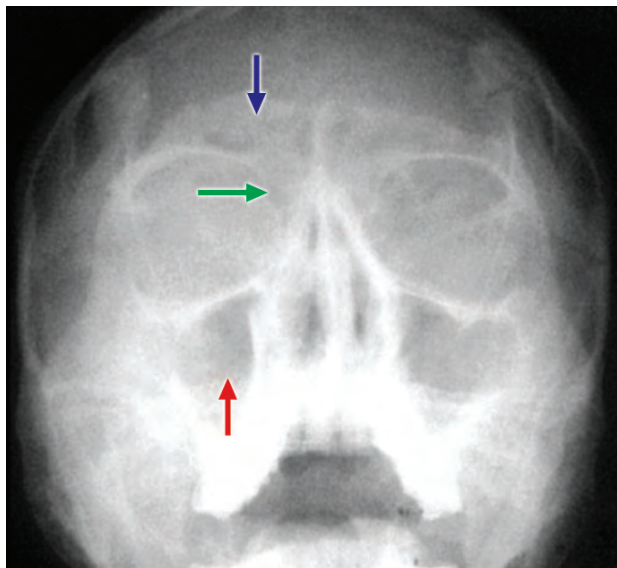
X-ray Towne's view showing frontal (blue), ethmoidal (green) and maxillary (red) sinuses
